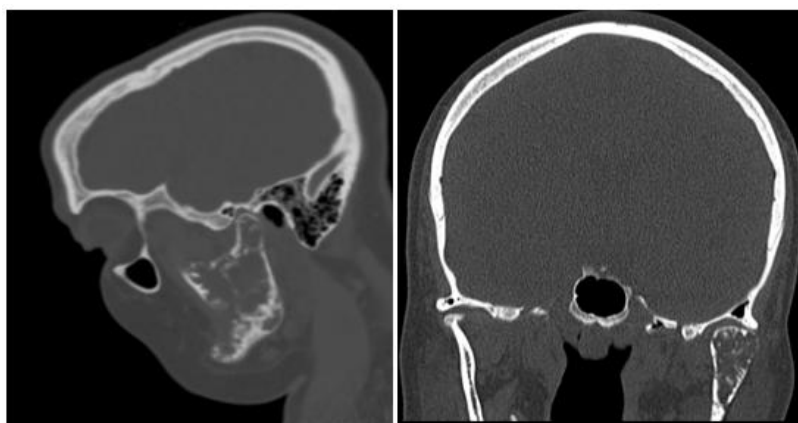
Facial CT, bone window, sagittal (1A) and coronal (1B) section: osteolytic lesion of the left hemi-mandible involving the ramus and the horizontal branch with blowing and rupture of the cortex in certain areas
